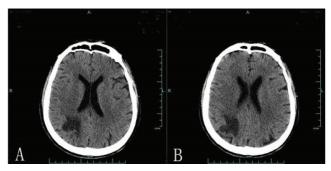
Computed tomography (CT) scans showing a hypodense region in the right occipital-parietal white matter.
